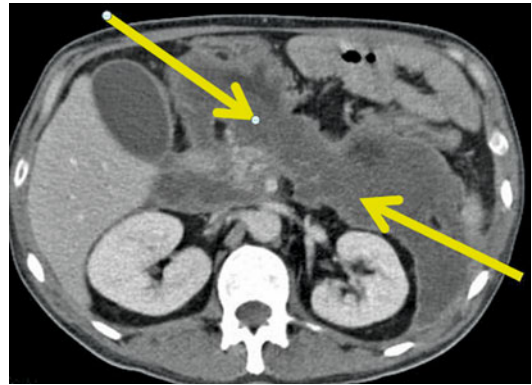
CT of patient with infected pancreatic and peripancreatic necrosis with *yellow arrows* indicating the commonly used left side percutaneous and less frequently used right oblique drainage routes
